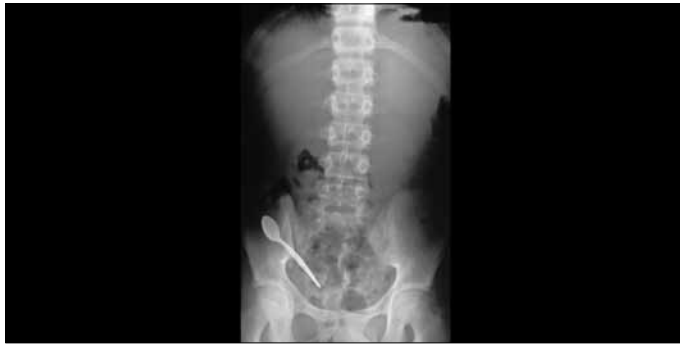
Standing direct abdominal radiograph shows a vertical teaspoon fixed in the right lower quadrant
